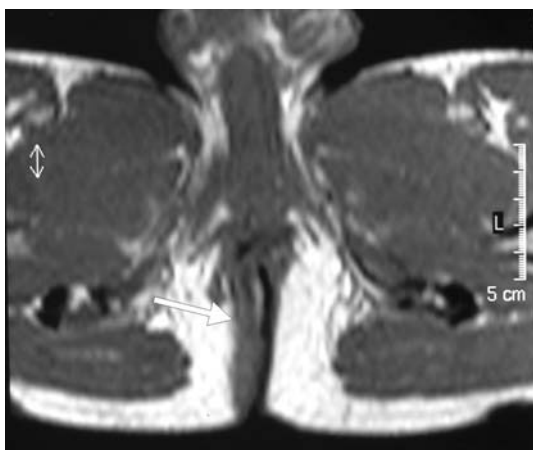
T1-weighted MR image is performed in axial plane and clearly visualizes longitudinal lesion recognized as a fistula (*arrow*) in the right ischioanal fossa.
